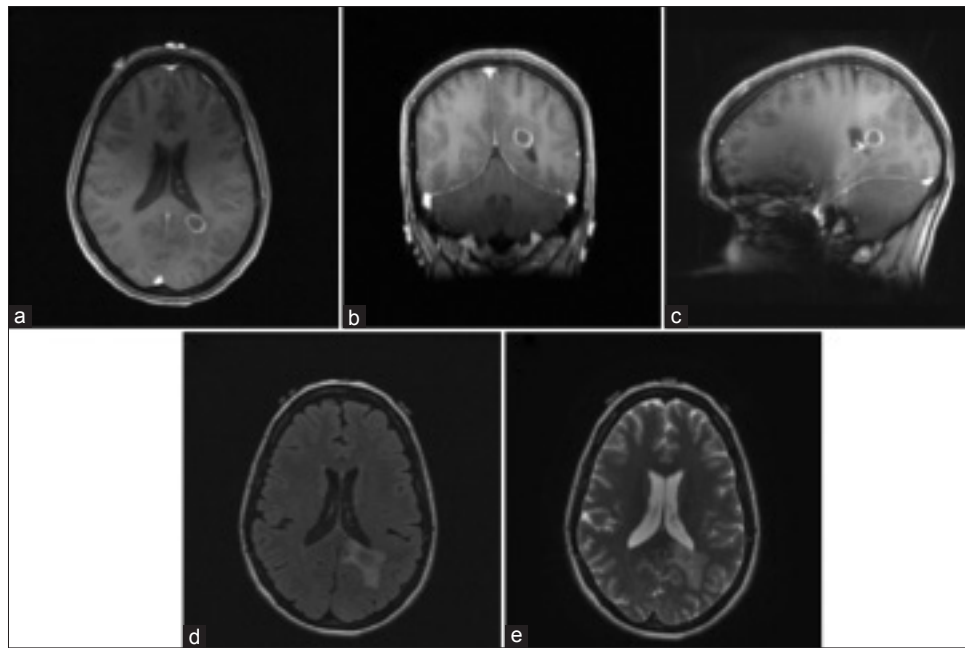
Magnetic resonance imaging of brain showing left parietal lesion. (a) Axial, (b) Coronal, (c) Sagittal T1-weighted images with gadolinium, (d) T2-weighted fluid attenuated inversion recovery axial without gadolinium, (e) T2-weighted axial without gadolinium
